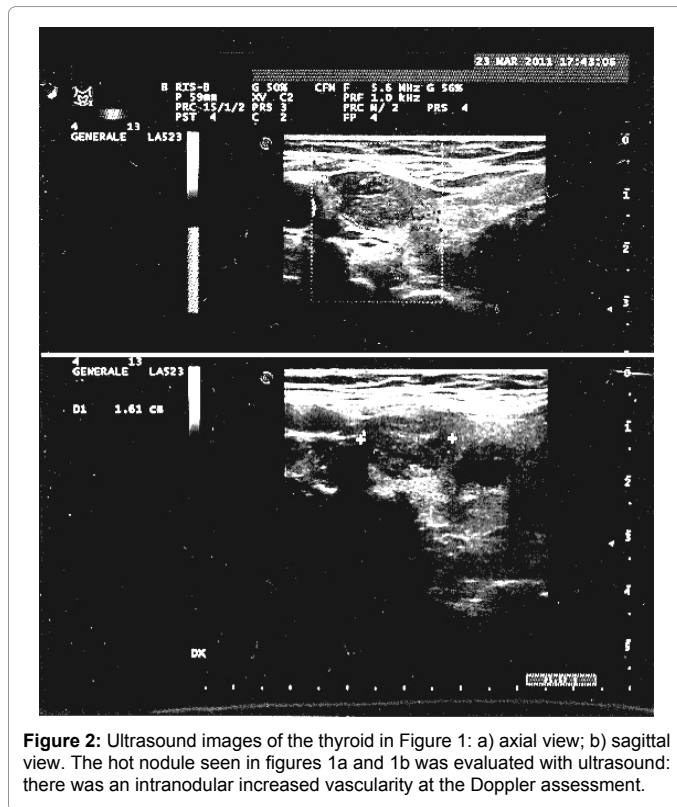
Ultrasound images of the thyroid in Figure 1: a) axial view; b) sagittal view. The hot nodule seen in figures 1a and 1b was evaluated with ultrasound: there was an intranodular increased vascularity at the Doppler assessment.
